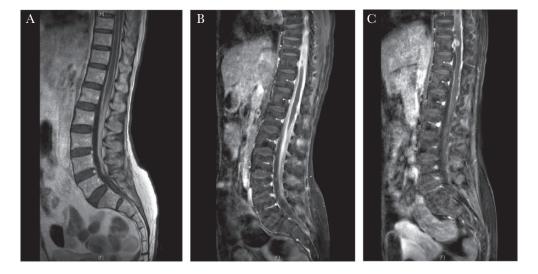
T1-weighted postgadolinium MRI brain images demonstrating evolution of spinal tuberculomas in Case 3; pre—and post—infliximab use. MRI of the spine at (A) time of presentation, (B) week 7 post—commencement of TB therapy with formation of spinal cord tuberculoma (pre-infliximab), and (C) week 21 post—commencement of TB therapy and after 3 doses of infliximab, demonstrating incomplete resolution of spinal cord tuberculoma. Abbreviations: MRI, magnetic resonance imaging; TB, tuberculosis.
